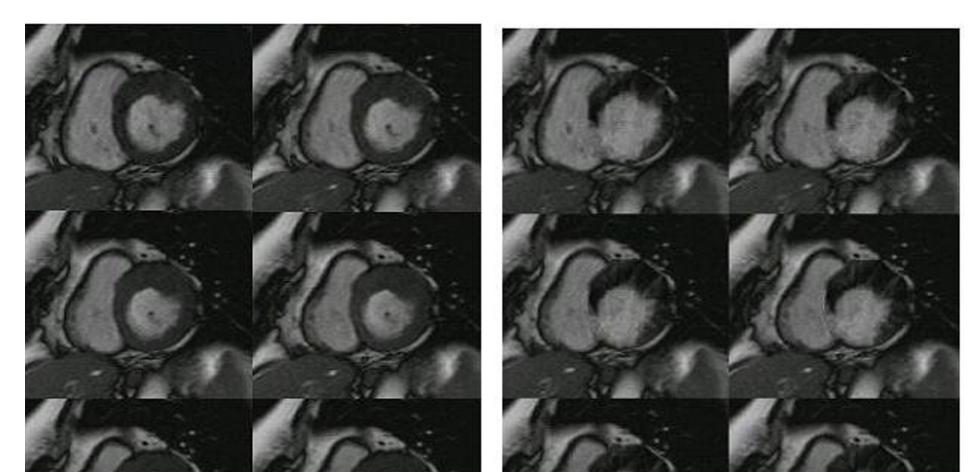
The comparison between the cine CE MR images and the original cine MR images.
